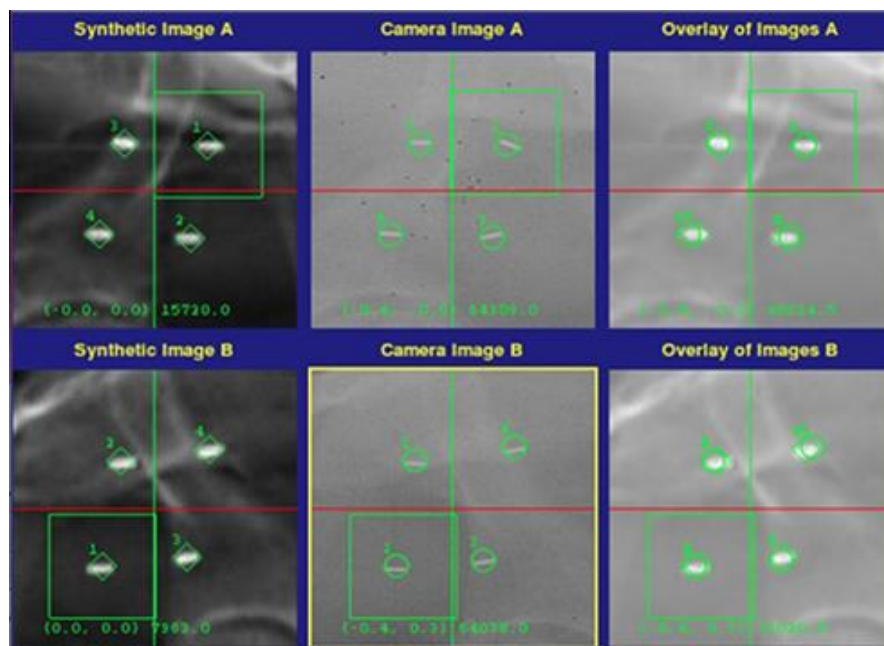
Auto-correction of prostate location on SBRT CyberKnife. Left: Location of fiducial markers on planning CT scan. Middle: Location of fiducial markers on real-time X-ray images captured by CyberKnife. Right: Super-positioning of CT and X-ray to align the prostate for treatment. All detected offsets are corrected by the robotic arm or by operator intervention during treatment [11].
